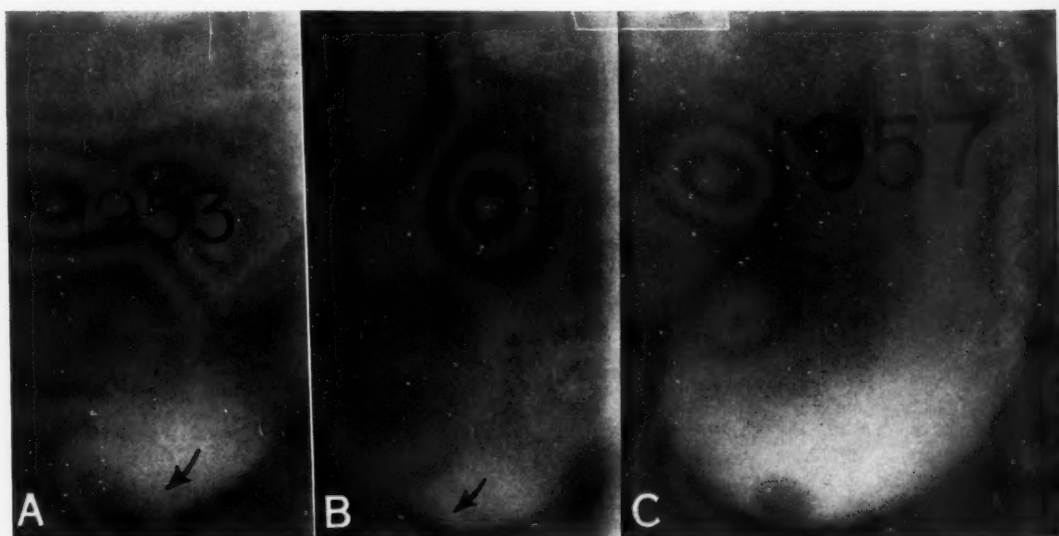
Roentgenograms made over a four-year span, (a) and (b) being in the erect position and (c) in the supine (no change was noted in the position of the fundal defect in 1957 with films made in the erect posture). The growth of the lesion (arrows) over a four-year period gave rise to some concern about the possibility of a true papilloma. Cholecystectomy was performed, and a solitary calculus measuring 1 cm. in diameter was found in the gallbladder; there were no polypi. Greater attention should have been paid to the thin line of dye separating the defect from the gallbladder wall.
